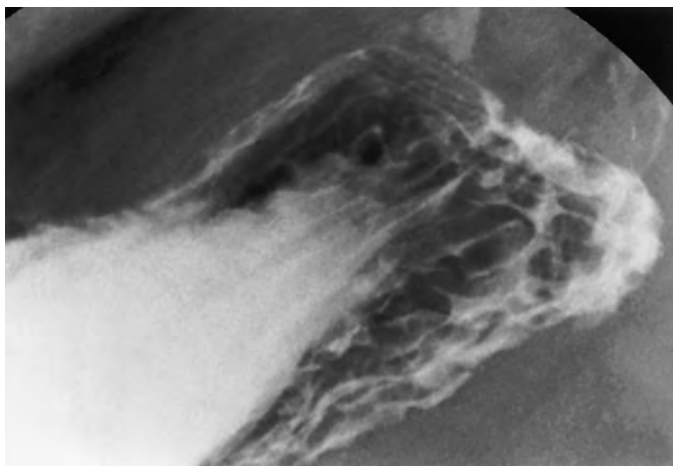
Portal hypertensive gastropathy. Thickened, nodular folds are seen in the gastric fundus. Note how the folds have an undulating contour and indistinct borders. Although gastric varices could produce a similar appearance, they tend to have a more serpentine configuration and are often manifested by discrete submucosal masses (see Fig. 34-1). (From Chang D, Levine MS, Ginsberg GG, et al: Portal hypertensive gastropathy: Radiographic findings in eight patients. *AJR* 175:1609–1612, 2000.)
